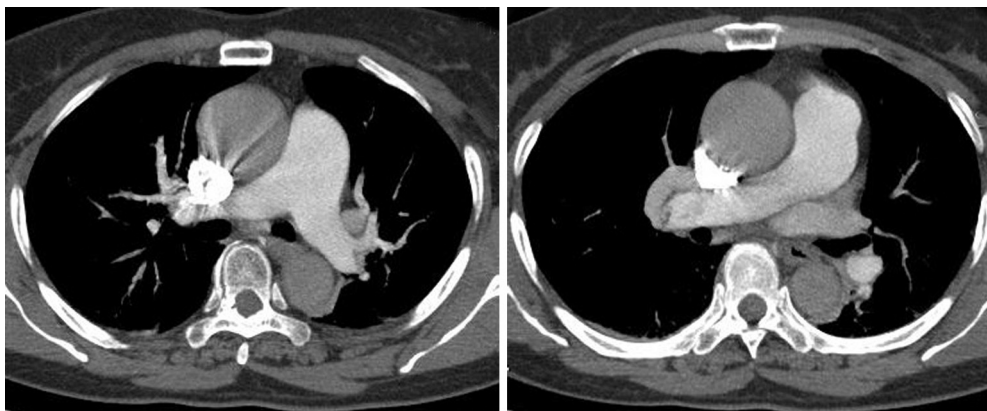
Enhanced chest CT scan at post treatment shows filling defects in the right main pulmonary and left inferior pulmonary arteries are improved.
